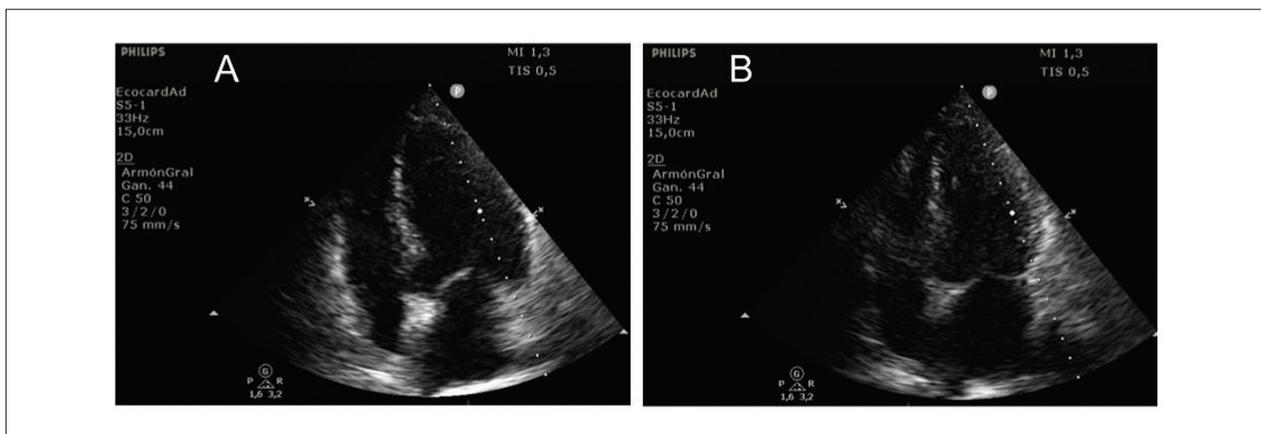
Transthoracic echocardiogram performed four weeks after discharge. Panel A shows the left ventricle in diastole, and Panel B in systole; the left ventricular ejection fraction (LVEF) was calculated at 60%.
